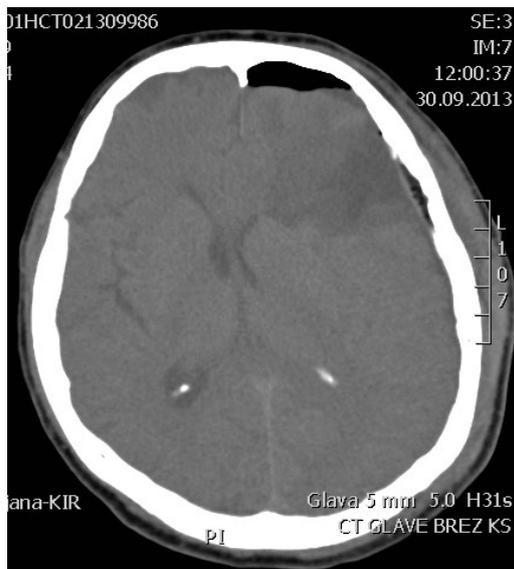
CT-scan after operation, showing tumor removal and mild edema.
